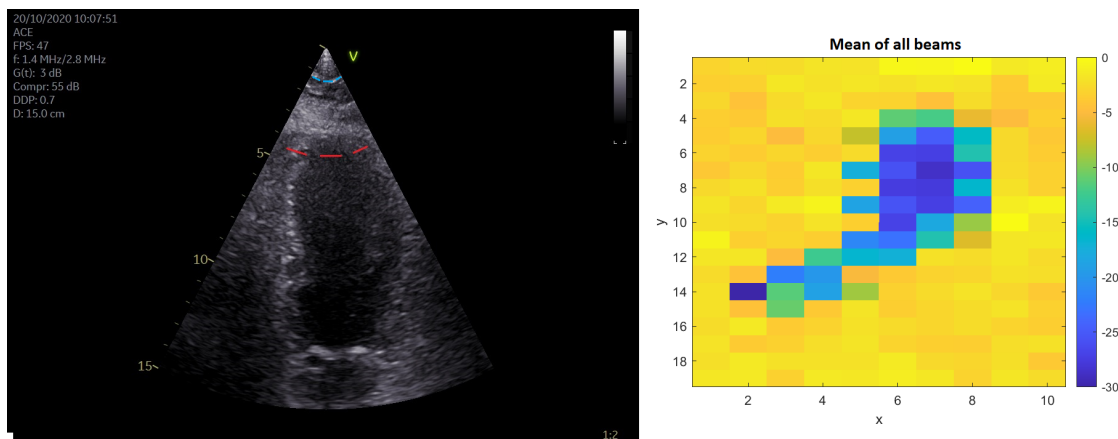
The ultrasound image and the corresponding amplitude plot of a special case where the energy is attenuated in a concentrated spot.
